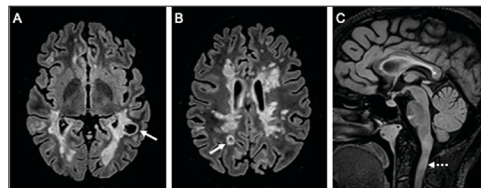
Post-immunotherapy brain MRI
